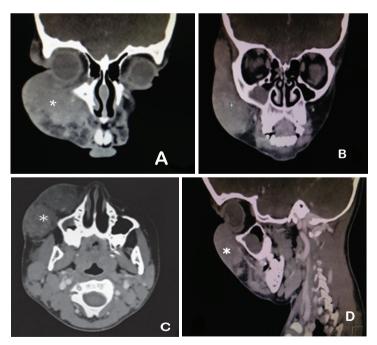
Computed tomography scan of facial bones and neck showing hypo- to iso-intense soft tissue mass at the right buccal region (asterisk): A, B) coronal view, C) axial view, and D) sagital view.
